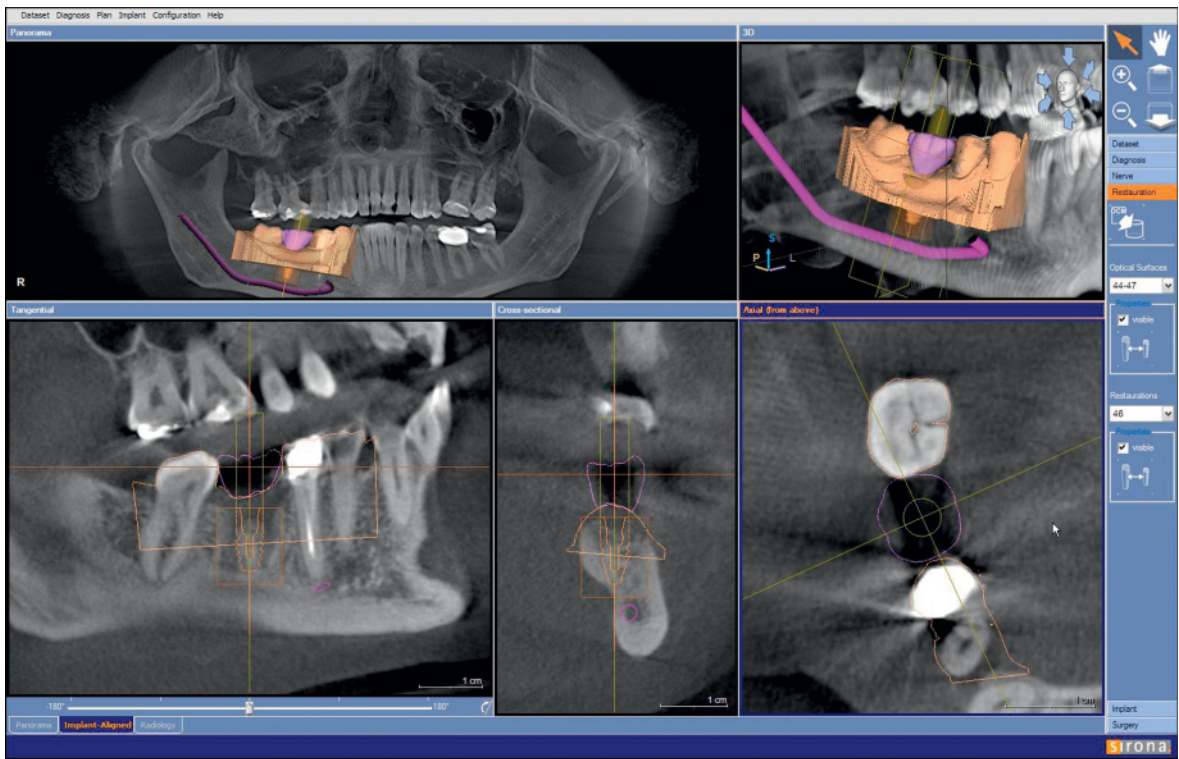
Virtual implant planning based on a virtual wax-up and three-dimensional X-ray dataset.
